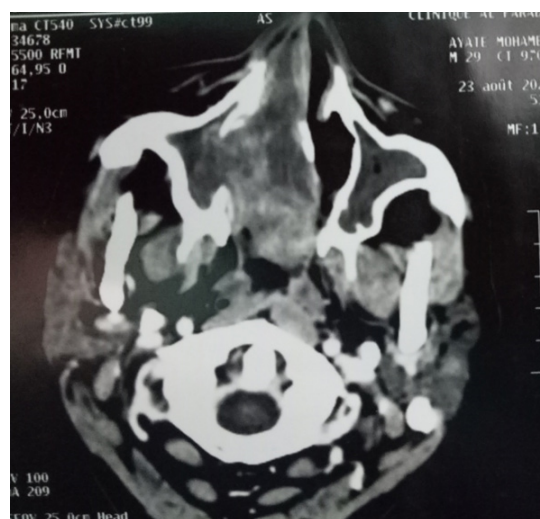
Nasosinusual Axial CT scan: large hemangioma of the right nasal cavity.
